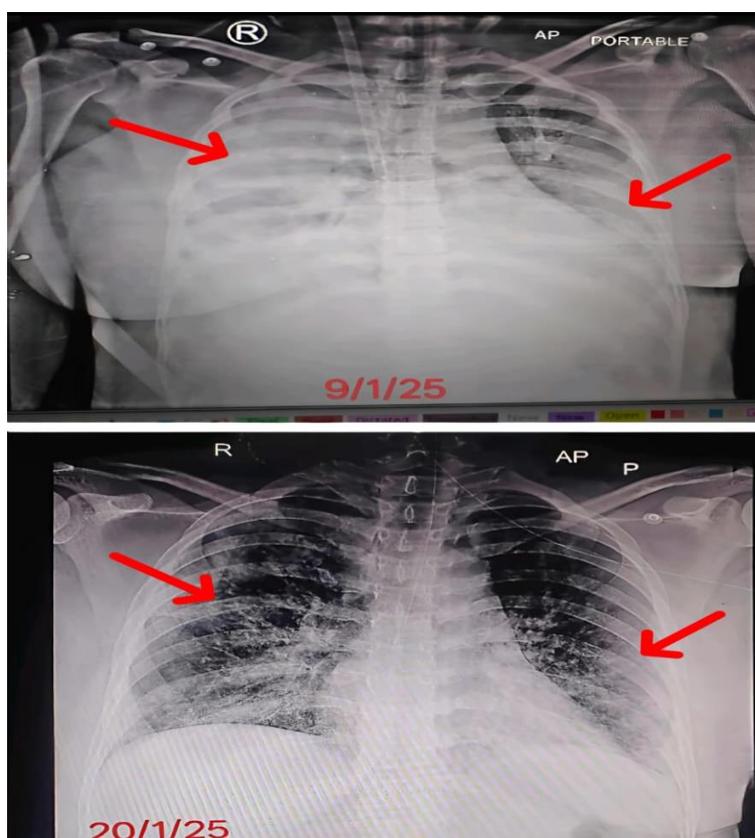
Chest X-Ray (9/1/25-20/1/25)
